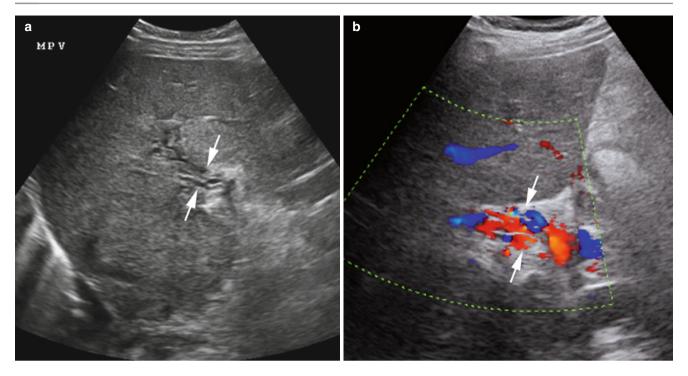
Cavernous transformation of thrombosed portal vein. (a) Sonogram through liver and porta hepatis showing several small vessels (*arrows*) where the portal vein should be visible. (b) Color
